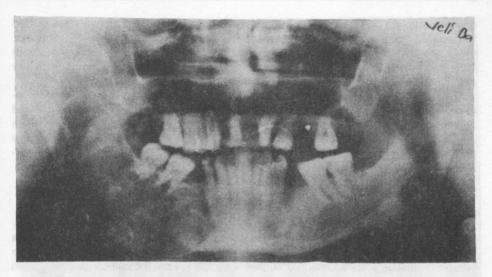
Radiograph showing the radiolucent lesion in the right mandible.
